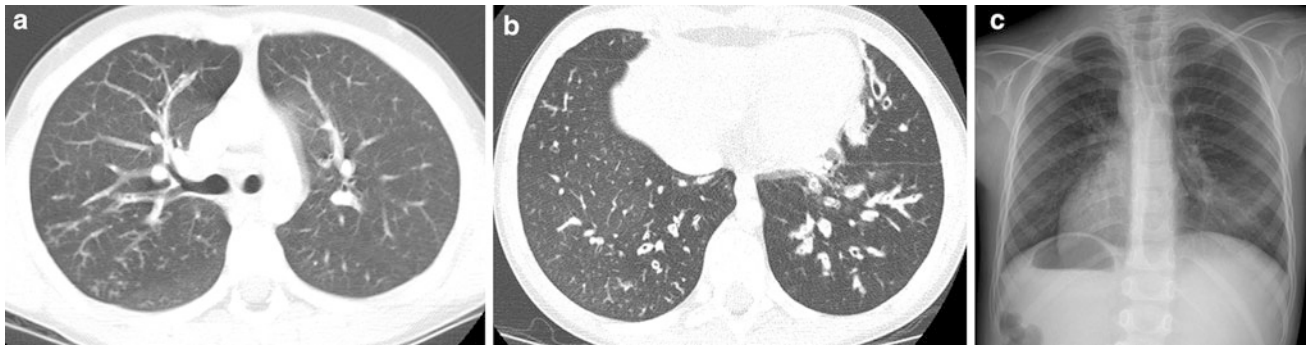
Primary ciliary dyskinesia (PCD). Axial chest CT images (a, b) from a 10-year old with a history of chronic sinusitis show bronchiectasis and bronchial wall thickening that resembles CF-related lung disease, but the lower lobe and lingular predominance are more
